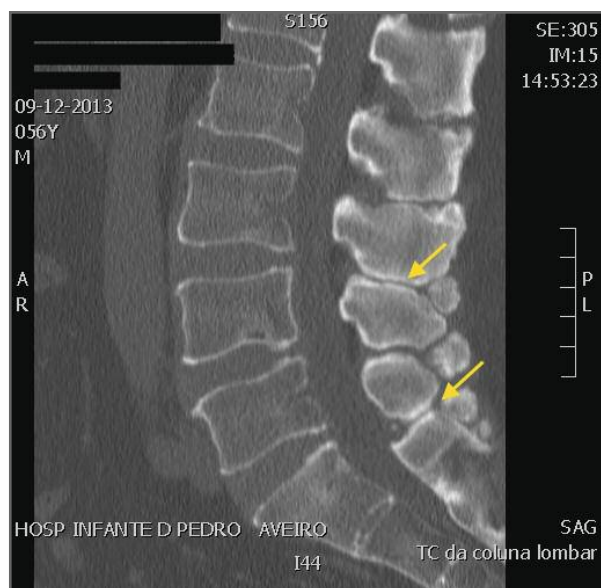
Lumbar CT (sagittal view) revealing approximation of the spinous processes with reactive sclerosis
